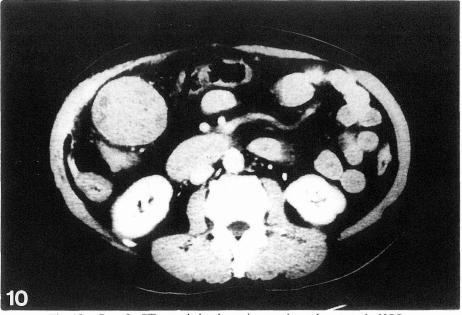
Case 3: CT revealed a large intraperitoneal metastatic HCC.
